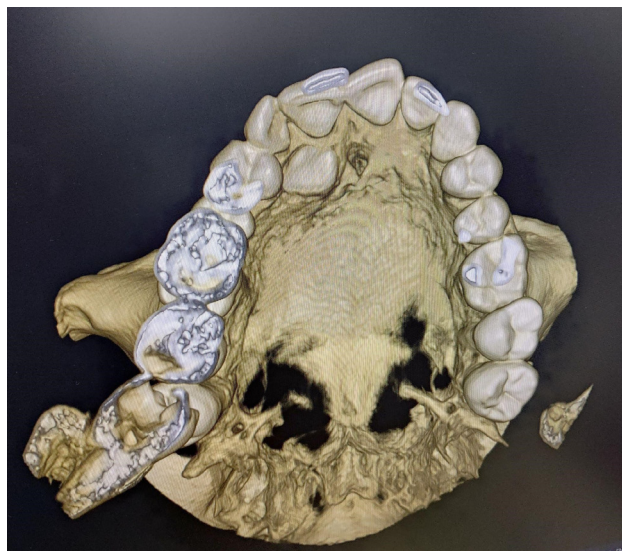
CBCT 3D image - palatal aspect.
